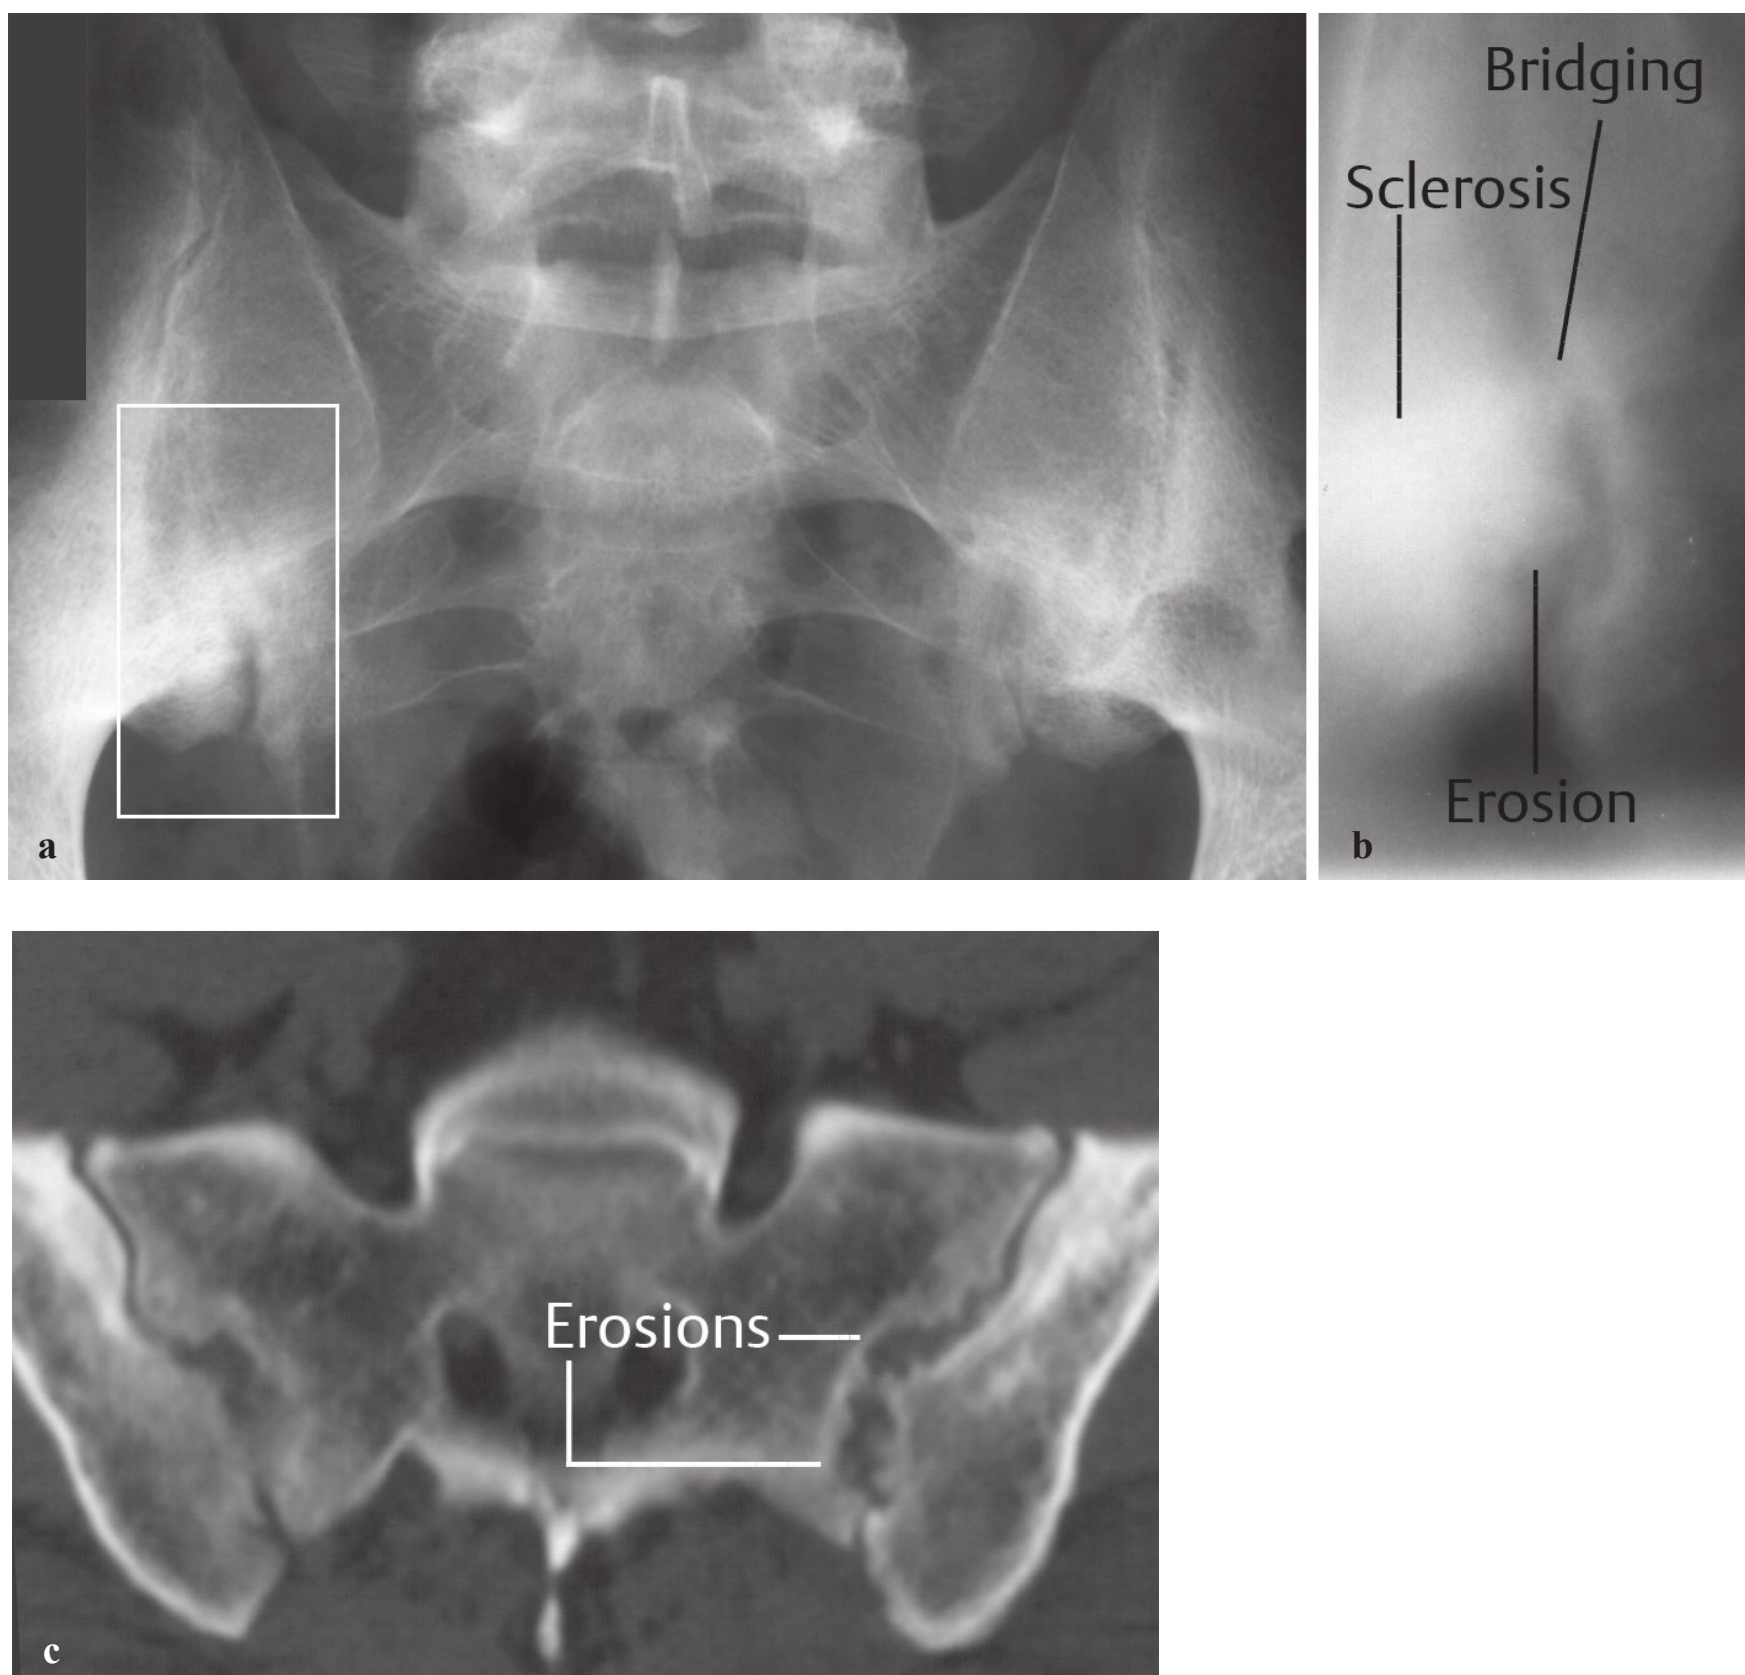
(a,b) Radiograph demonstrating sclerosis and erosion at the sacroiliac joint. (c) Axial computed tomographic image demonstrating erosions at the sacroiliac joint. (From Bohndorf K, Imhof H, Pope TH Jr. *Musculoskeletal Imaging: A Concise Multimodality Approach*. Stuttgart, Germany: Georg Thieme Verlag; 2001: Figs. 9.112, 9.113. Reproduced with permission.)
